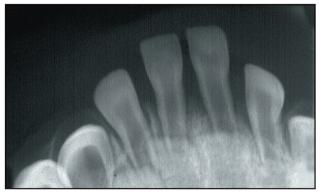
Radiographic examination showing normal development of mandibular incisors.
